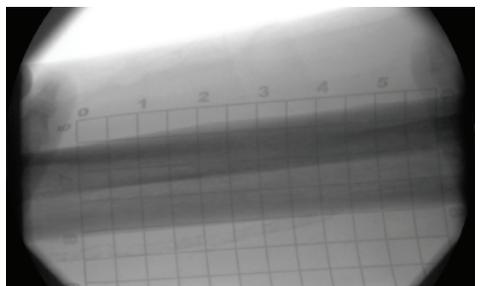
With X-Grid, a target vein was localized with a single fluoroscopic X-ray.
